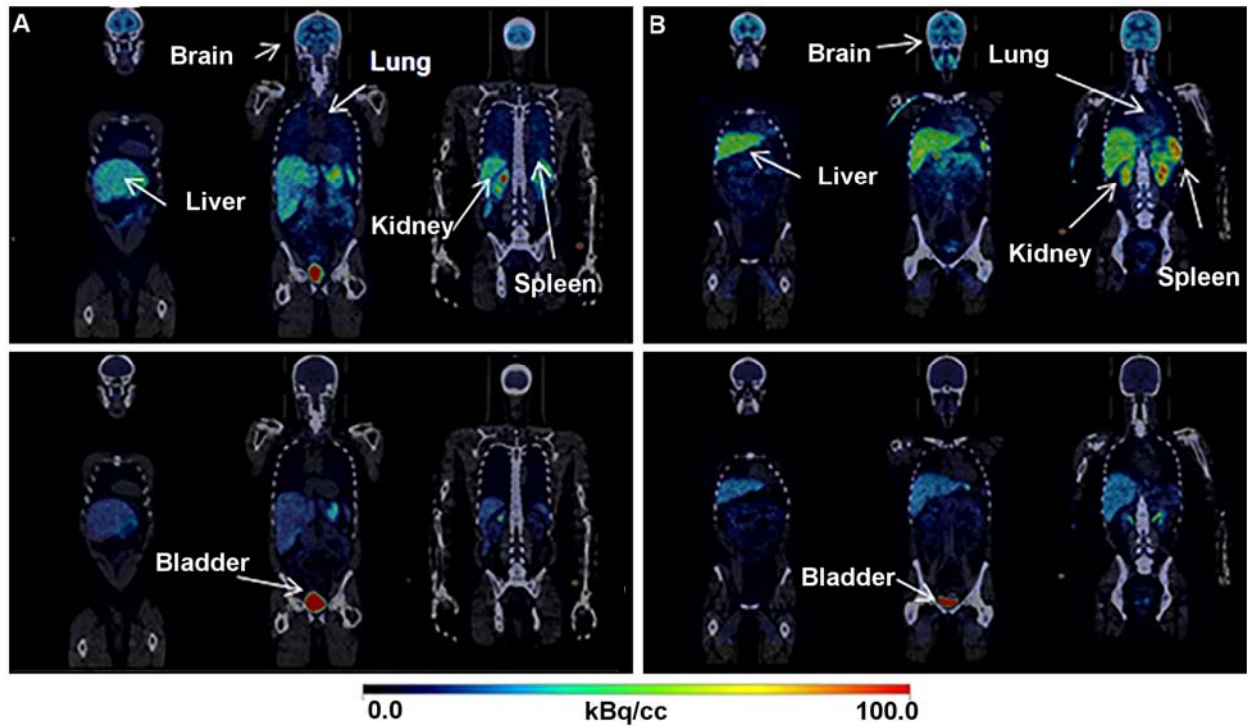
Coronal view of representative 2.8 min (top rows) and 22.6 min (bottom rows) whole body PET/CT images of a male (A) and a female (B) subject. The early images clearly delineate the brain, liver, spleen, lungs, and kidneys. The late images show an intense accumulation in the urinary bladder. The brain, liver, lungs, spleen, and kidneys are less conspicuous in the late images (bottom row) than seen in the early images (top row) indicating a significant washout/clearance of radioactivity from these organs with time.
